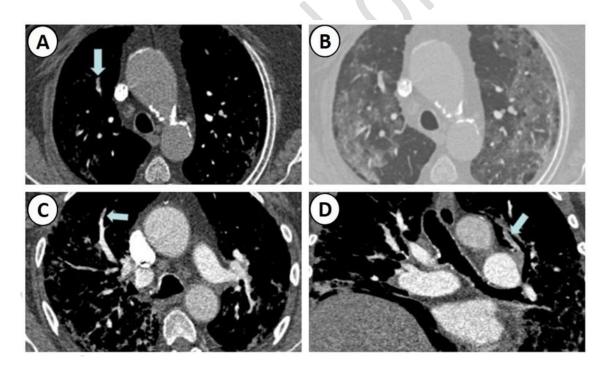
Abbreviations: computed tomography pulmonary angiogram; PT, Pulmonary thrombosis.
